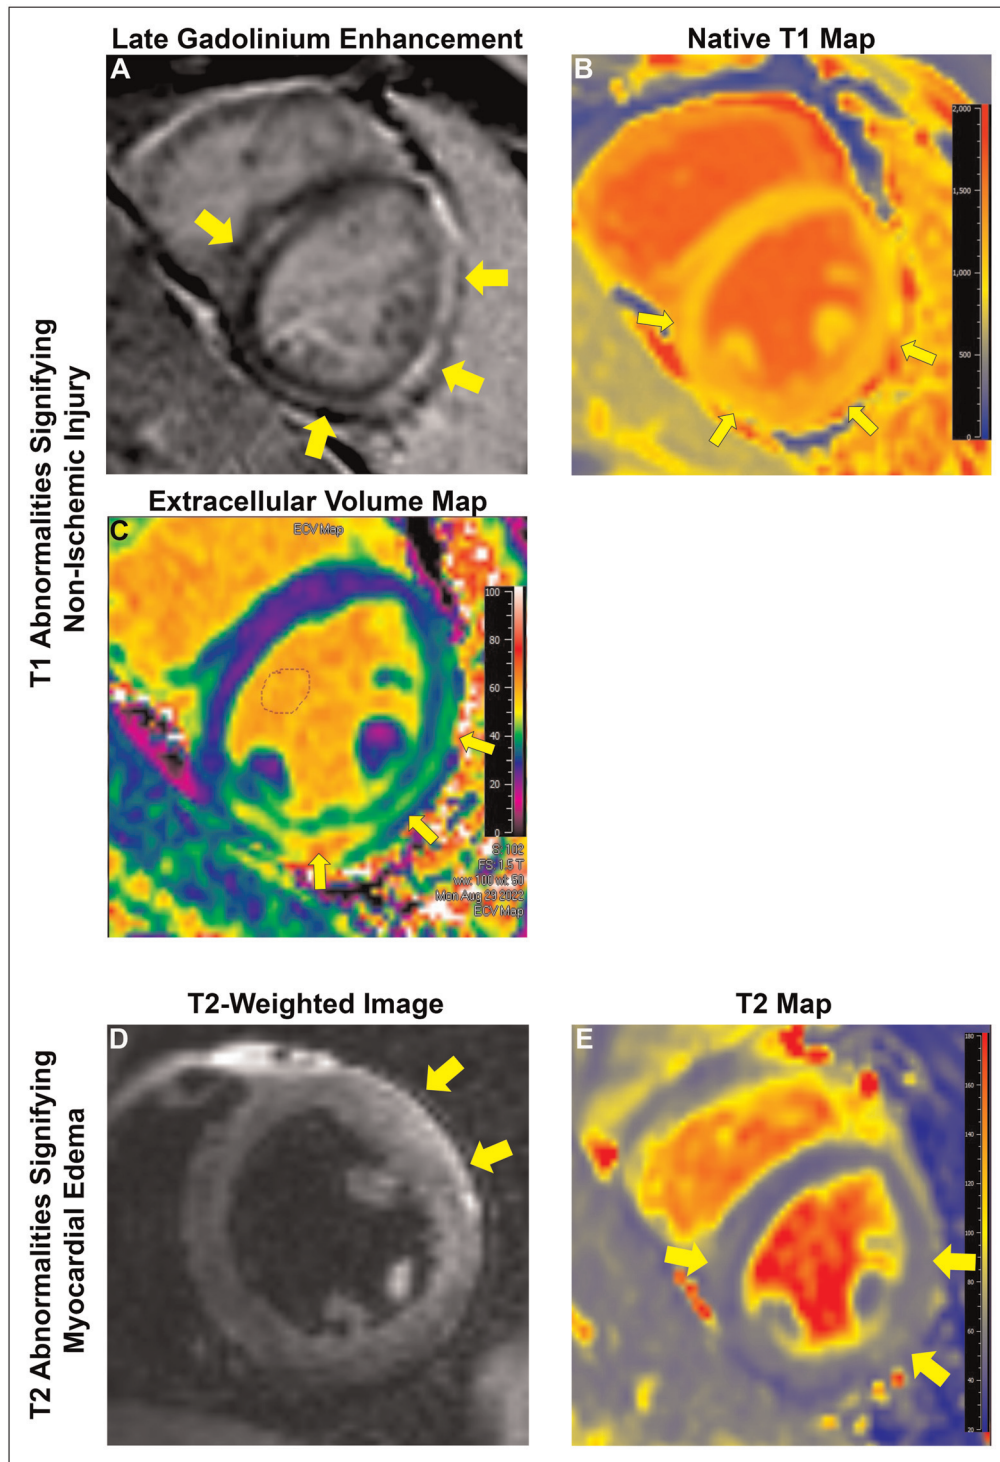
Cardiac magnetic resonance (CMR) images in the short axis from patients with myocarditis revealing abnormalities in T1 (nonischemic injury) and T2 (myocardial edema), as required by the updated Lake Louise Criteria for diagnosis of myocarditis. (a) Late gadolinium enhancement (LGE) in the subepicardium of the free wall and inferoseptal segment (arrows); (b) native T1 map, and (c) ECV map in the same patient with high T1 and ECV in a similar pattern to the LGE (arrows); (d) T2-weighted image in a different patient demonstrating myocardial edema in the anterolateral segment (arrows); (e) T2 mapping (same patient from Fig. 1a–c) with high T2 times consistent with edema in the free wall and inferoseptal segment (arrows).
